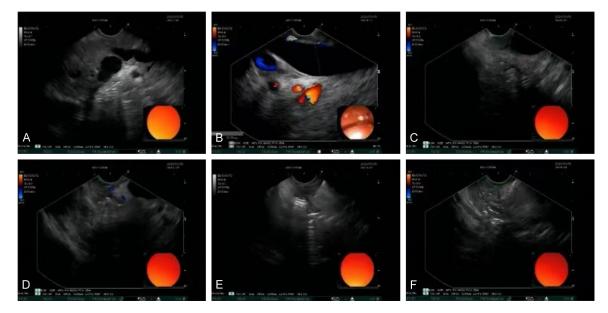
Endoscopic ultrasonography and ultrasound puncture images. A: Gallbladder; B: Common bile duct; C: Pancreas; D: Pancreatic head; E: Papilla echo; F: Bleeding at the puncture site. Ultrasound diagnosis: 1. Papillary inflammation and adenoma; 2. Dilatation of the common bile duct; 3. Dilatation of the main pancreatic duct.
